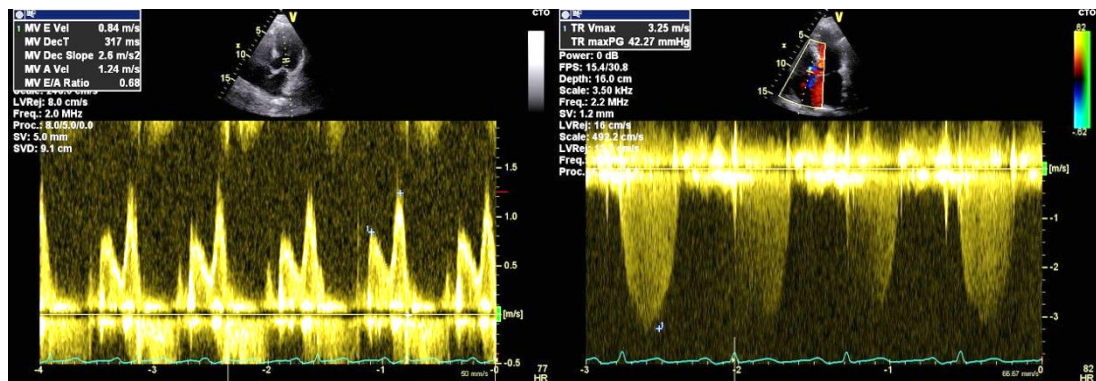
To the left a pulsed Doppler registration of the inflow to the left ventricle, in the small 2D image above you see the cursor with the marking showing where the velocities are recorded. To the right a continuous Doppler registration of the regurgitation from the tricuspid valve, in this case the maximum velocity along the whole cursor is registered.
